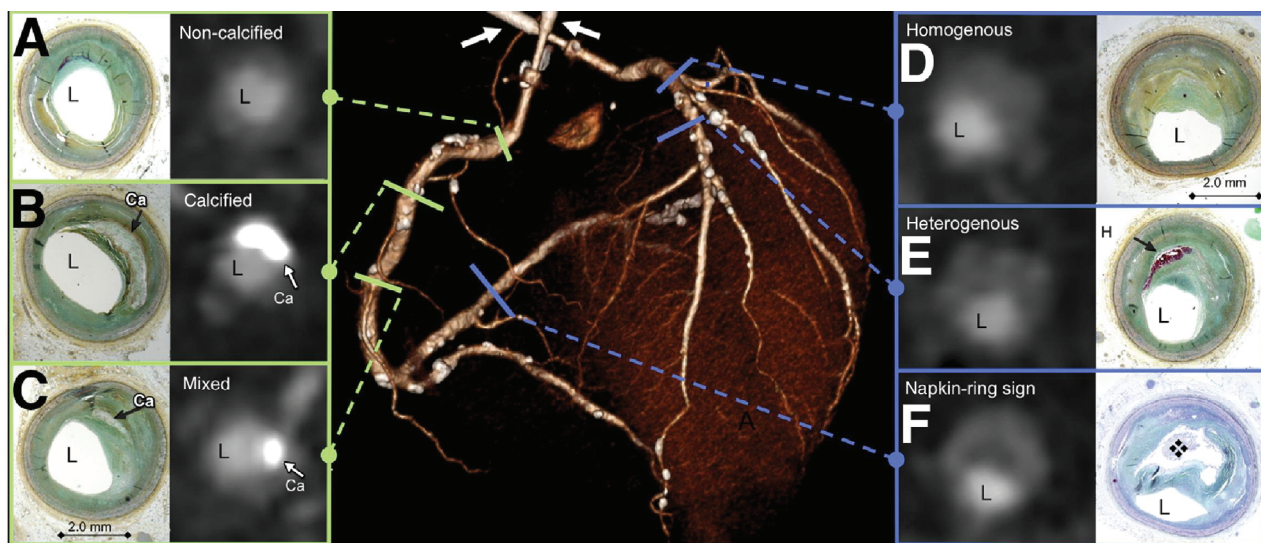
Traditional and Attenuation Pattern–Based Plaque Classification Schemes in Coronary Computed Tomography Angiography (CCTA).
